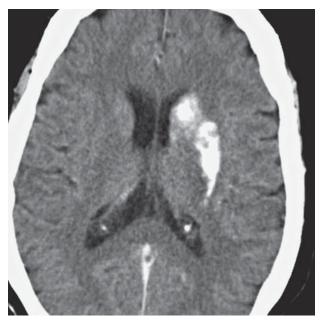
Patient* 3. Immediate post-operative CT scan shows contrast media - and possibly blood - extravasation into the basal ganglia. The cerebral cortex shows no evident lesions.
